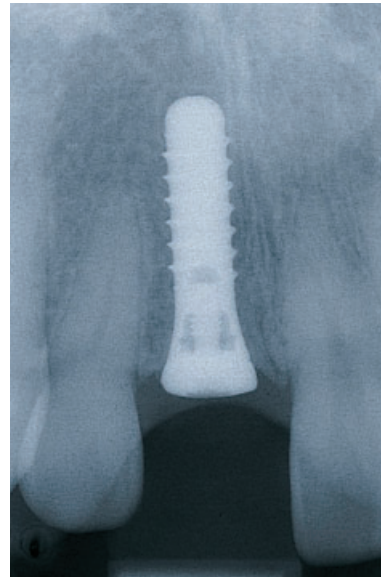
The corresponding radiograph displays a continuous close contact between bone and implant and confirms that the vertical interproximal bone level has been maintained.
